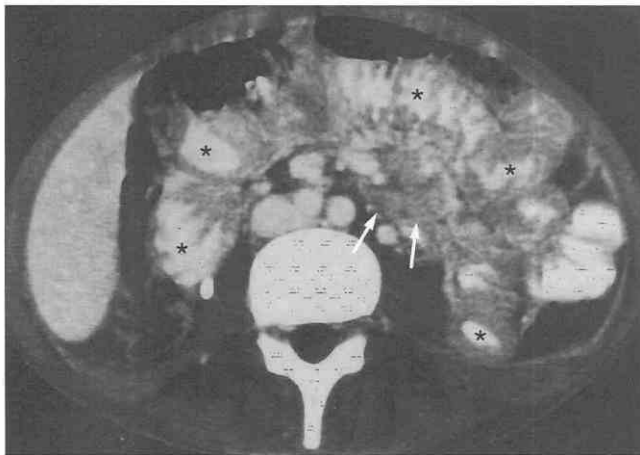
Mycobacterium avium-intracellulare* enteritis. CT scan shows concentric bowel wall thickening (asterisks) of the small-bowel loops with evidence of bowel dilatation and fold thickening. Mesenteric lymphadenopathy (arrows) is also seen. (Courtesy of K. C. Cho, M.D., Newark, New Jersey.)
